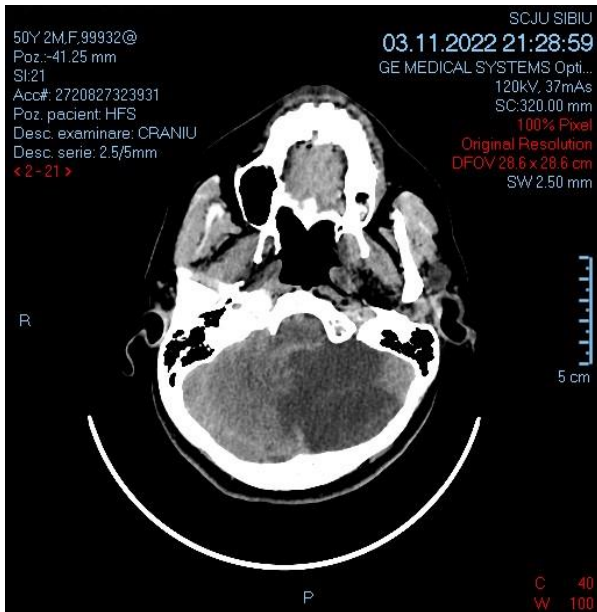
Native CT Head performed on 03.11.2022.
